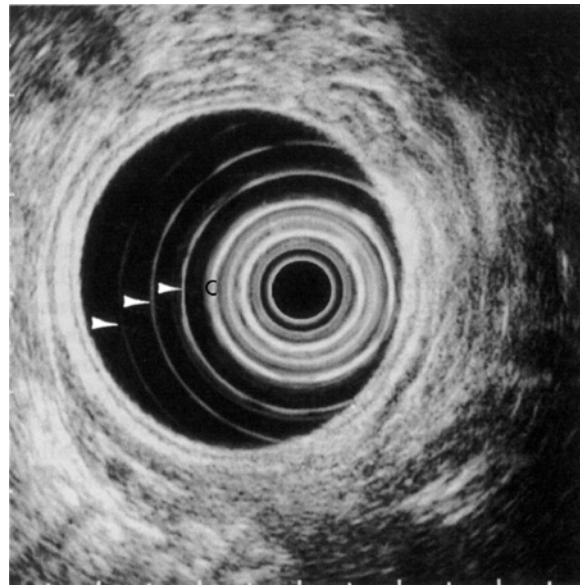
The plastic casing (C) around the ultrasound transducer produces a strong reverberation of the ultrasound beam between the transducer and the casing. This results in a series of circular rings (arrows) of equal spacing and diminishing amplitude around the transducer.
